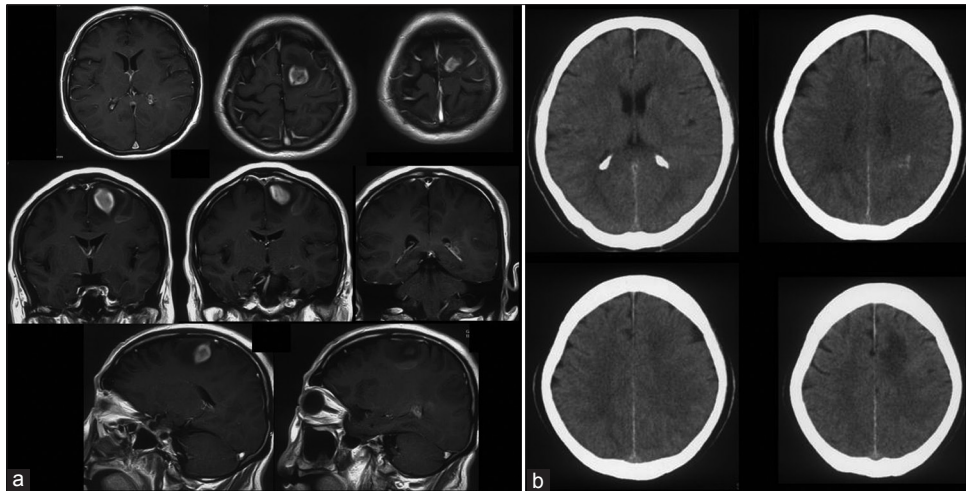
(a) Magnetic resonance imaging (MRI) enhanced by contrast media obtained at the first hospitalization. Multiple brain tumors in the left parietal and left paraventricular region were observed. Upper: axial view, middle: coronal view, lower: sagittal view. (b) Computed tomography (CT) scan at the first hospitalization. Microbleeding in left paraventricular region was observed
